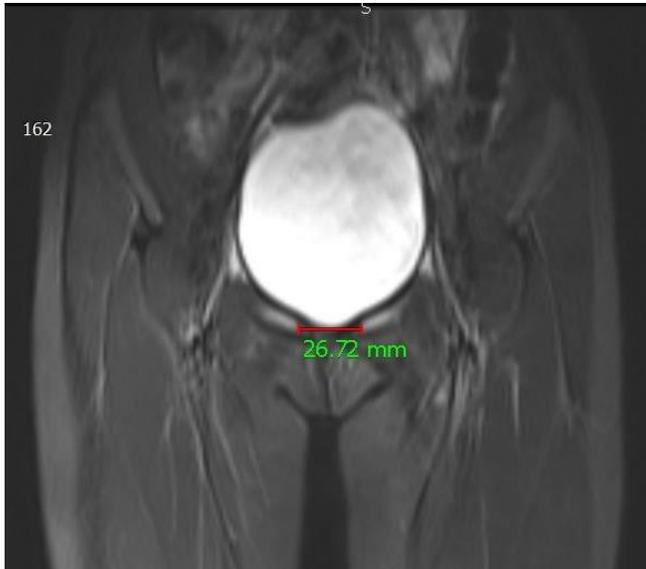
Coronal and axial MRI view of pelvis showing widening of the symphysis pubis
